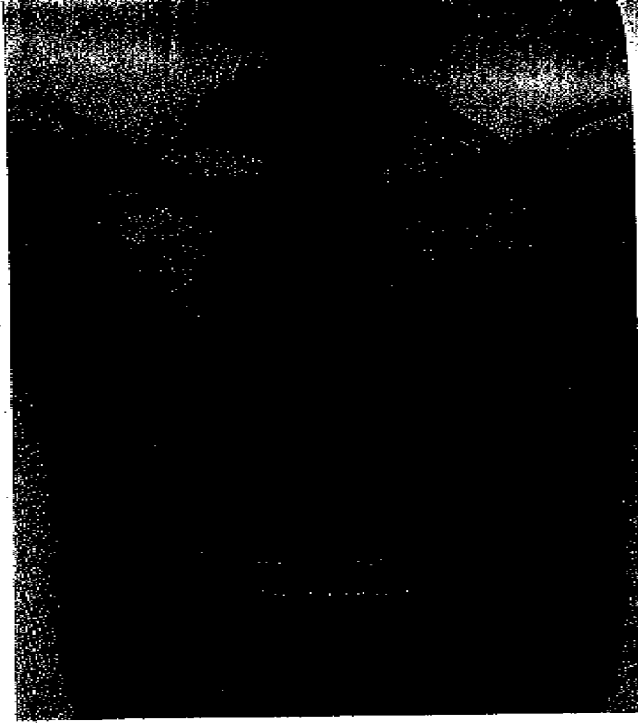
Roentgenogram of the chest of a female aged 27 years, and an asbestos worker for 8 1/2 years. The appearance indicates a fairly well advanced stage of asbestosis. Note the increased prominence of hilum and trunk shadows and the linear and interstitial fibrosis of the lower lung fields. The costophrenic angles and left cardiac border are characteristically indistinct. Note the absence of nodular appearances. Reproduction furnished through the courtesy of Dr. J. V. Sparks, London.
